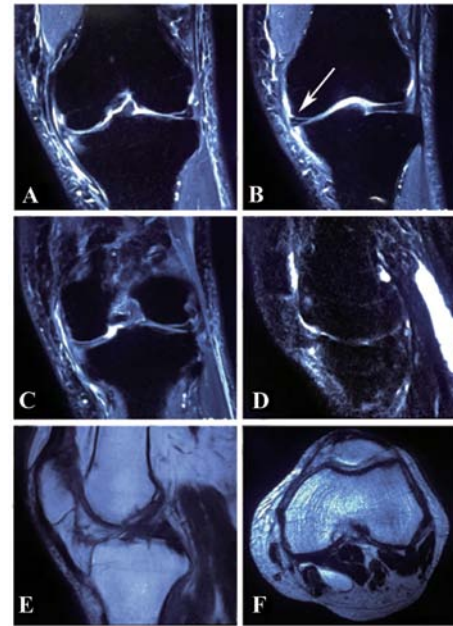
MRI prior to the first arthroscopic surgery. (A) Bone marrow edema in the lateral tibial plateau margin. (B) Horizontal high signal in the medial meniscus extending into the articular capsule of the meniscus, as indicated by the arrow, in the T2-weighted MRI coronal section implied the medial meniscus tear. (C) No evidence of osteonecrosis in the proximal tibia and distal femur. The patellofemoral facet had been degenerated (D) in the T2-weighted MRI and (E) T1-weighted MRI (figure E). (F) Cross-section of the distal femur. None of the coronal, sagittal and cross-sectional views of the pre-operative T1- and T2-weighted MRI exhibited any evidence of osteonecrosis of the medial femoral epicondyle prior to the arthroscopy surgery.
